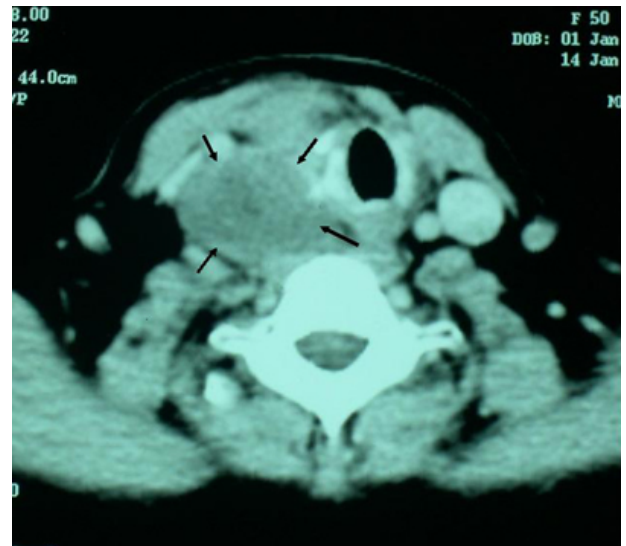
CT imaging in 5th postoperative month
